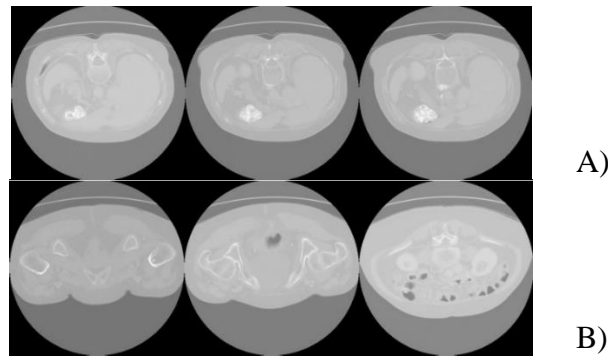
Samples of CT DICOM images from LiTs dataset: liver slices without tumor (A), liver slices with tumor (B)
